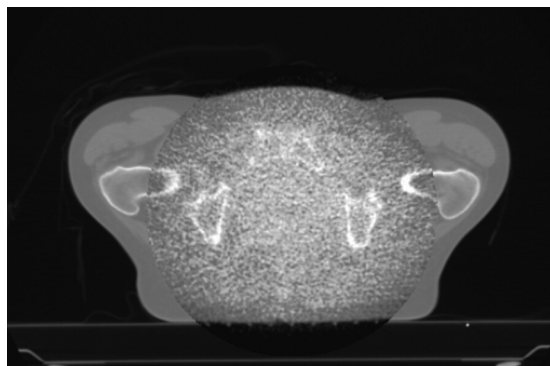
Co-registered planning CT and MV-CT data sets can be concatenated to compensate for the limited field of view of the MV-CT image.
